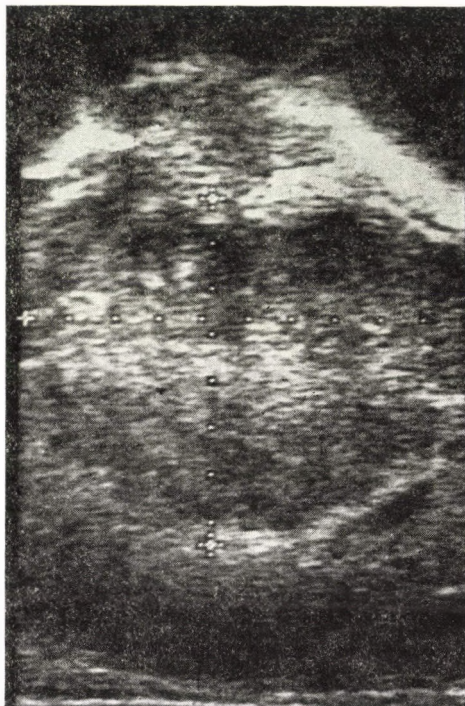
Sonographic scan of retroperitoneal lymph node
